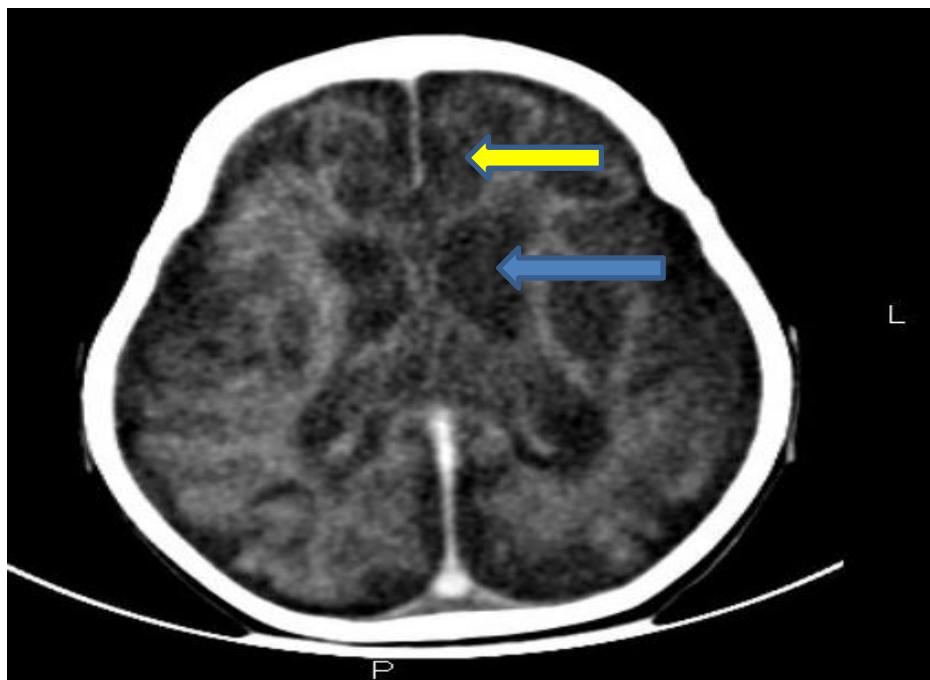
Axial image of the brain following an enhanced computed tomographic scan at the level of the lateral ventricles showing: prominence of the lateral ventricles (left blue arrow) and multiple CSF density spaces (left yellow arrow) in both cerebral hemispheres with poor grey-white matter interphase.
